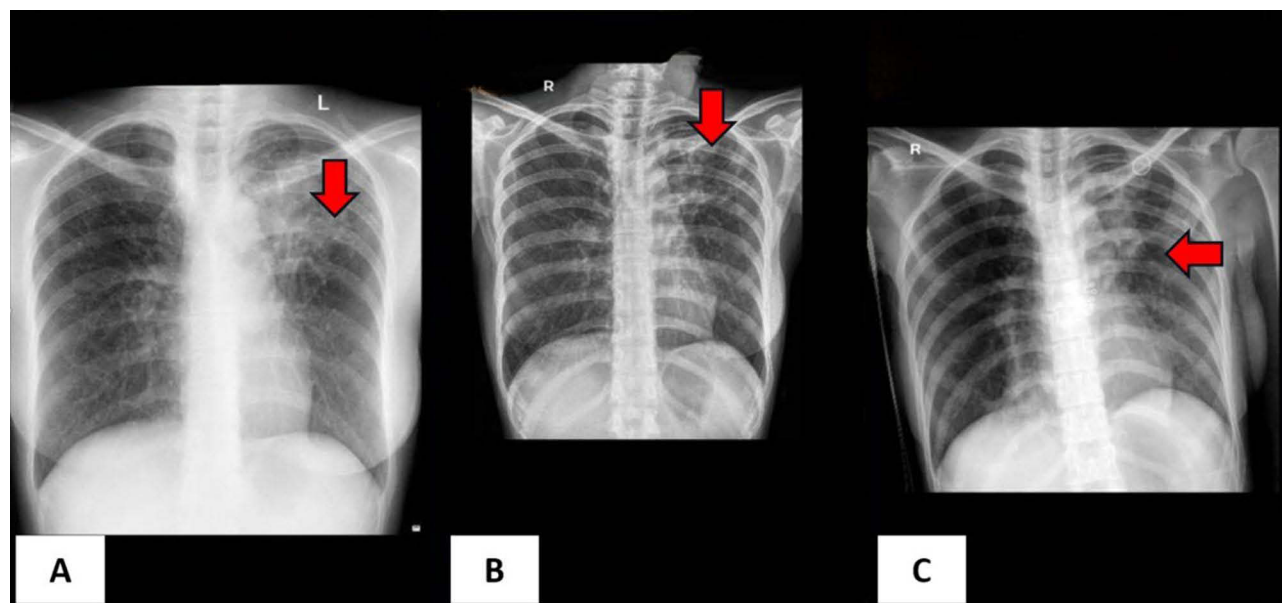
Chest X-ray. (A) Chest X-ray (posteroanterior view) 12 August 2024, showing features consistent with active pulmonary tuberculosis characterized by fibro-infiltrates and multiple cavities in the upper zone of the left lung, associated with superior retraction of the left hilum (red arrow). (B) Chest X-ray (posteroanterior view), after 1 year (25 August 2025), demonstrating active pulmonary tuberculosis with partial radiologic improvement compared to image A (red arrow). (C) Chest X-ray (posteroanterior view) in September 2025, revealing active pulmonary tuberculosis with fibro-infiltrates and cavitary lesions in the upper and mid zones of the left lung (red arrow), showing radiologic progression compared to image B.
